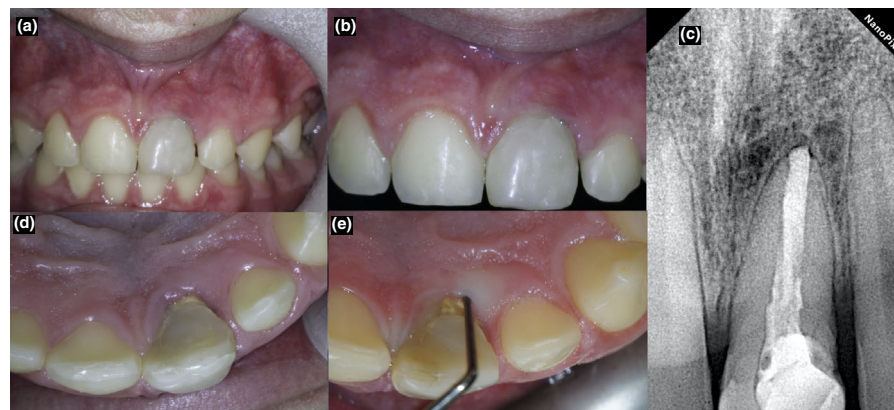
(a) Postoperative labial clinical view, (b) Postoperative palatal clinical view, (c) periapical radiograph after splint removal, (d) postoperative labial clinical view after splint removal, e. postoperative palatal clinical view after splint removal. (Images taken by a Canon EOS 400D / EF100mmf /2.8 Macro lens, digital sensor Gendex Visualix- eHD).
